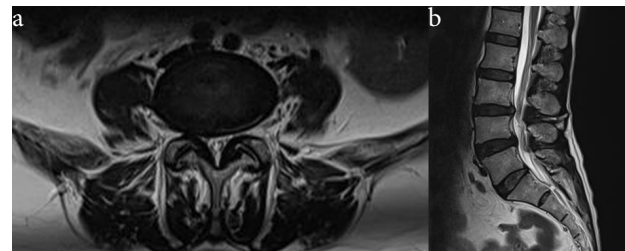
Axial T2-weighted image at the L4–L5 level (a) and midsagittal T2-weighted image of the lumbar spine (b) in a 67-year-old woman with low back pain demonstrating asymmetric disc bulging at the L4–L5 level. Note. Disc degeneration was classified as Grade IV according to the Pfirrmann grading system, characterized by a dark gray disc with loss of distinction between the nucleus and annulus and slightly decreased disc height. Facet joint degeneration was classified as Grade I according to the Weishaupt grading system, with narrowing of the facet joint space, small osteophytes, and mild hypertrophy. Lateral recess stenosis was graded according to Bartynski's classification as Grade II on the right and Grade I on the left.
